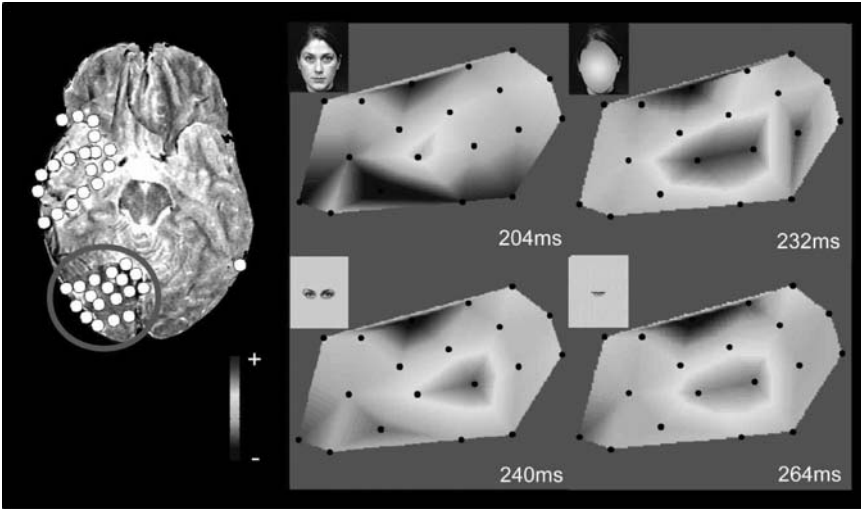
Example of a voltage topography map created from a grid of intracranial electrodes sited on the surface of the brain, seen here from its underside in an MRI based reconstruction (left). The voltage distributions elicited in response to faces and face parts over the occipitotemporal cortex show both positive and negative voltages at key time points following stimulus onset. The gray scale displays voltages from $\pm 200 \mu\text{V}$.
